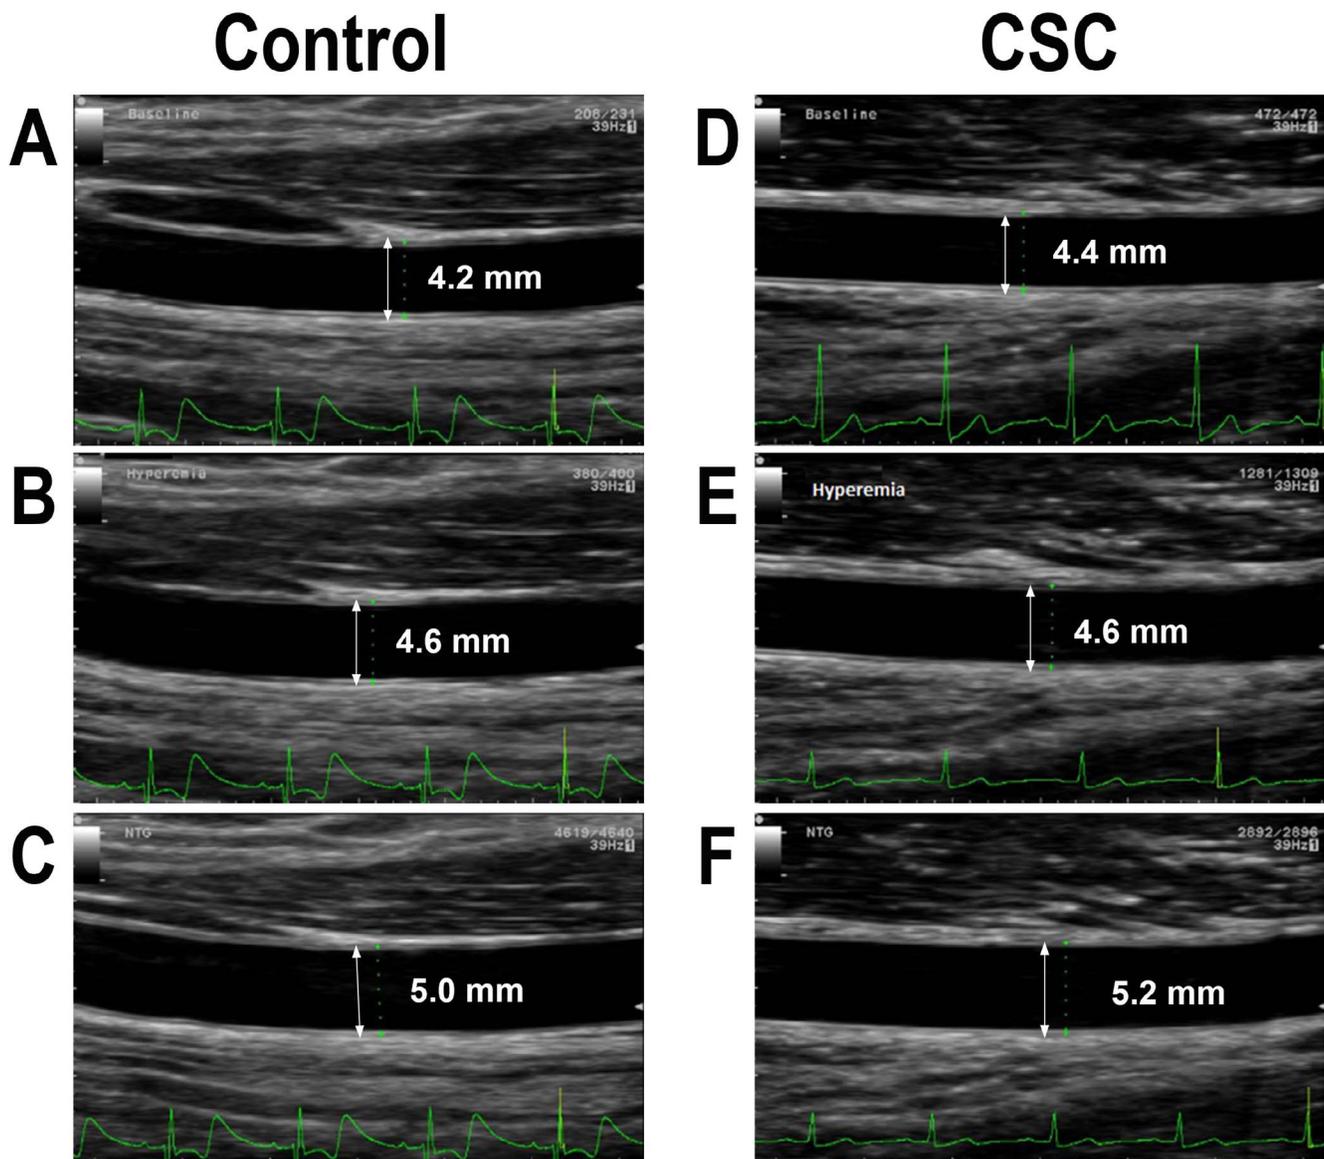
Two-dimensional high-resolution ultrasound images of the brachial artery at baseline (A), 60 seconds after cuff release (B), and 4 minutes after nitroglycerin sublingual spray (C) of a control subject, FMD = 9.52% and NMD = 19.05%; brachial artery at baseline (D), 60 seconds after cuff release (E), and 4 minutes after nitroglycerin sublingual spray (F) of a CSC patient, FMD = 4.55% and NMD = 18.18%, respectively.
